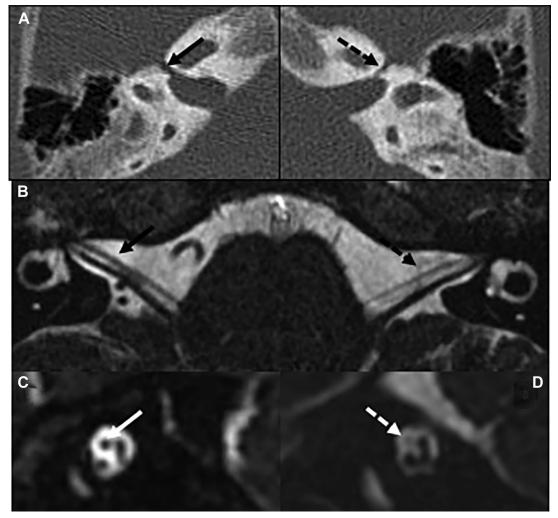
Facial canal and facial nerve hypoplasia. Axial CT (*A*), axial (*B*) and bilateral sagittal oblique CISS from right (*C*) and left (*D*) IACs, showing left facial canal and facial nerve hypoplasia (*dotted arrows*) compared with the normal-sized canal and nerve (*straight arrows*) on the right.
